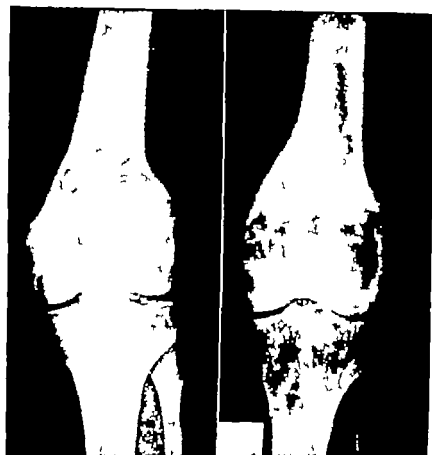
Giant cell tumor. A. Original roentgenogram. B. Result 11 years after roentgen therapy. good functional result.
